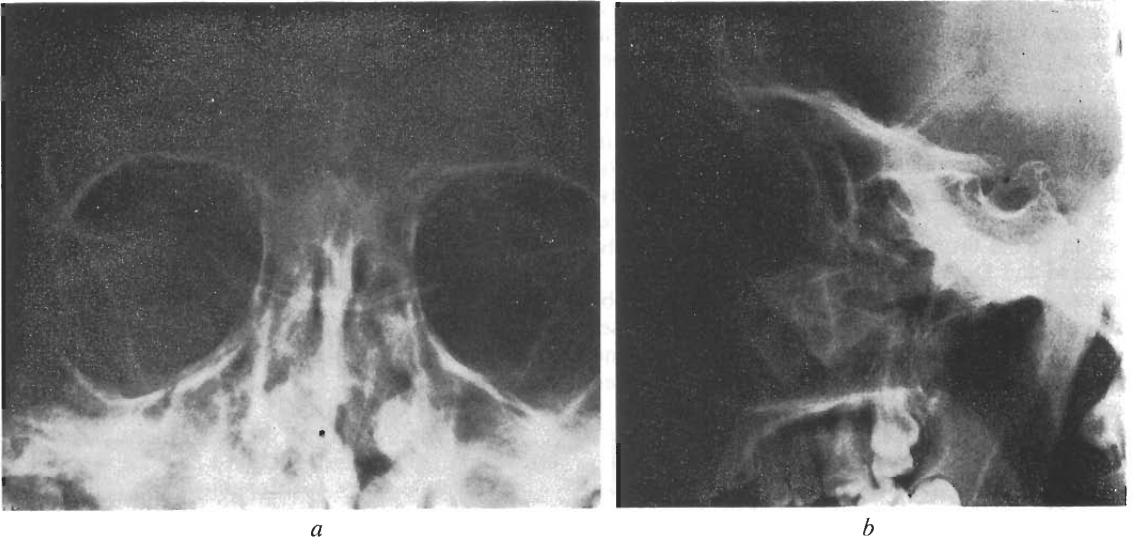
Postero-anterior (a) and lateral (b) skull X-rays showing aplasia of the frontal sinuses and hypoplasia of sphenoidal sinuses.
